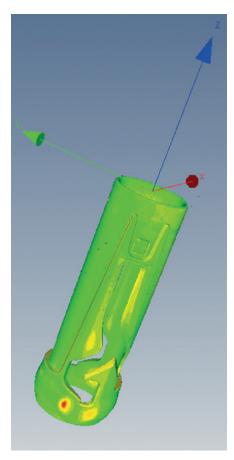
X-ray data is used to show the difference between the measurements taken by different tools and deviations from the CAD model.
